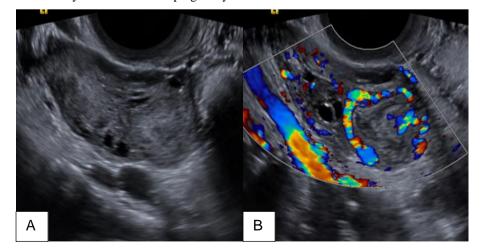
An 18-year-old female patient comes to the emergency department complaining of disabling pelvic pain. In the ultrasonographic examination, an image of ovoid morphology, a diameter of 20 mm, with a thin wall, heterogeneous content, and peripheral color Doppler signal, findings highly suggestive of a ruptured follicle, is identified.
